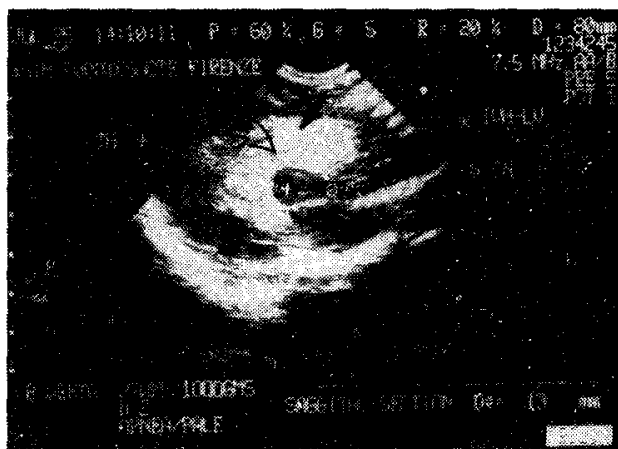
Para-sagittal sonogram (Rt) showing severe intraventricular hemorrhage (open arrow) surrounding the hypoechoic thalamus (TH) with extension into cortex (arrow).
